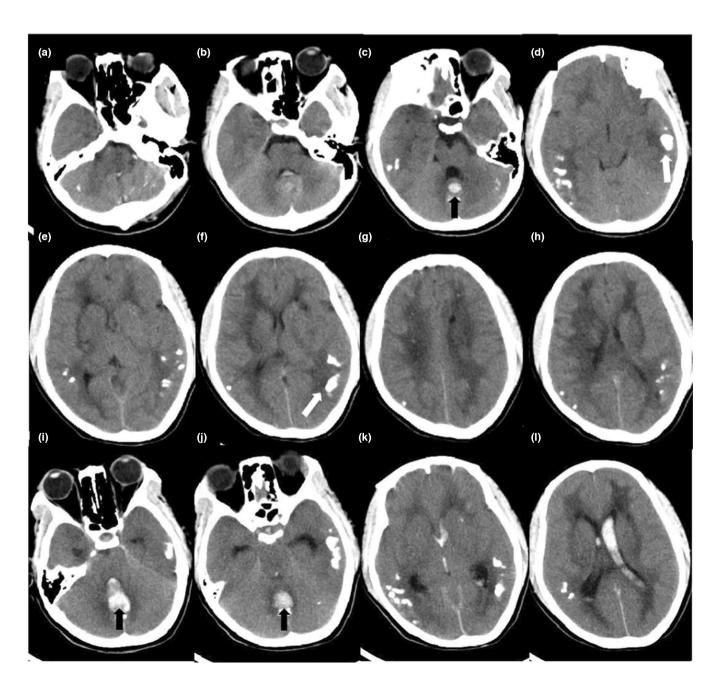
Brain CT showed cerebellar hemorrhage, white matter abnormalities, and calcifications. (a–h) First CT images on admission. (i–l) Second CT showed enlarged hemorrhage. White arrows indicate calcifications in the cortex. Black arrows indicate cerebellar vermis hemorrhage and hemorrhage breaking into ventricles.
